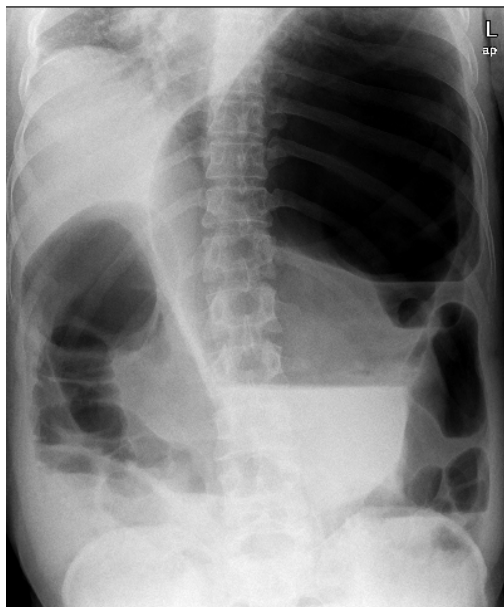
Plain x-ray showing two widely separated air fluid levels in splenic flexure and cecum
